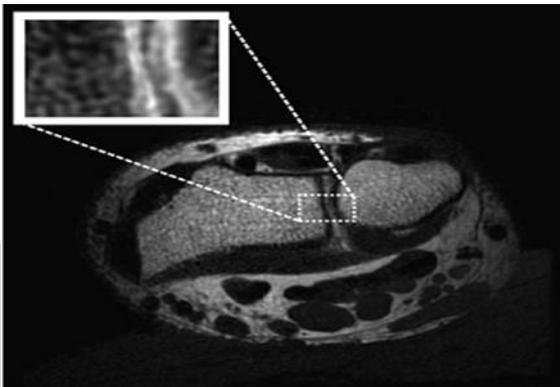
Cross-sectional magnetic resonance image of a human forearm
